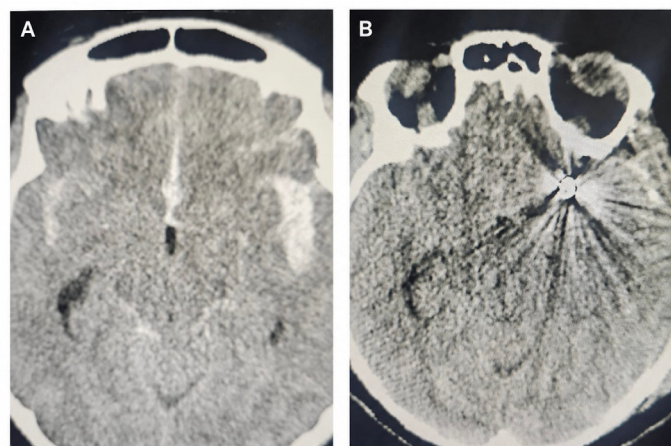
Representative cranial CT images of a patient with a ruptured middle cerebral artery aneurysm and an unfavorable functional outcome; (A) Preoperative cranial CT showing subarachnoid hemorrhage; (B) Postoperative cranial CT demonstrating the aneurysm clip
